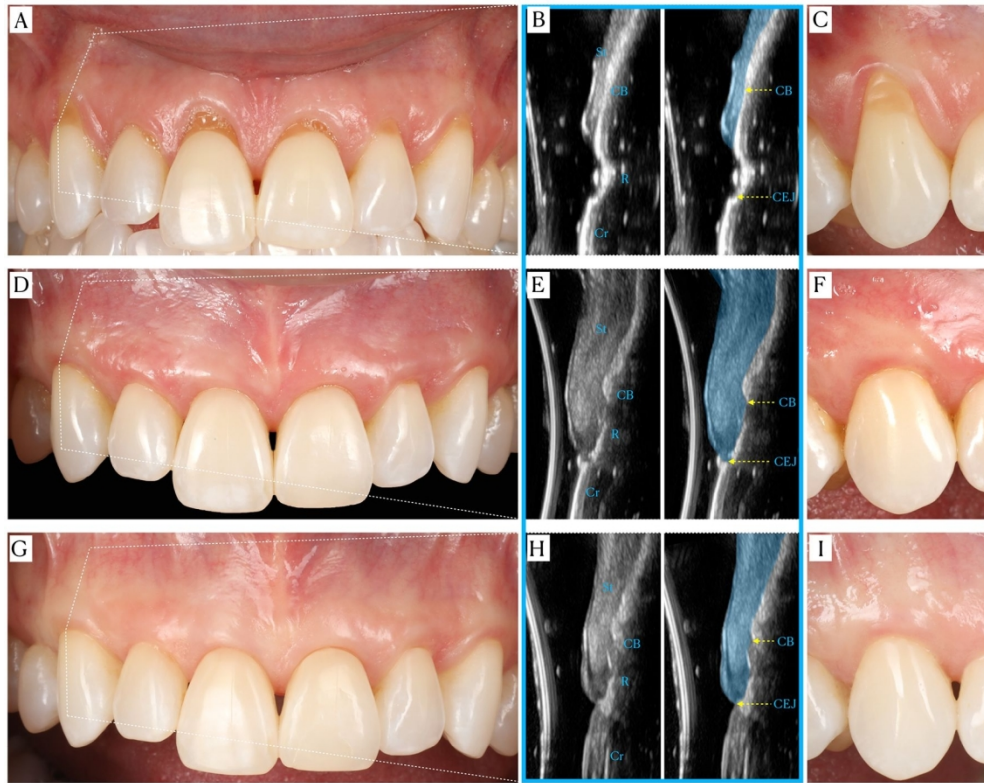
Clinical and ultrasonographic outcomes of the case 1. A) Baseline. B) Ultrasonographic scan of the midfacial aspect of tooth #6, where the clinical crown ("Cr"), the root ("R"), the crestal bone "CB", the cemento-enamel junction ("CEJ") and the soft tissue ("St") are pointed out. Note that the CEJ, CB and the soft tissue are highlighted in the second scan. C) Clinical presentation of the canine at baseline. D) 6-month outcomes. E) Ultrasonographic scan of the midfacial aspect of tooth #6 at 6 months. Note the reduction of buccal bone dehiscence (distance between CEJ and CB) compared to the baseline. F) Clinical presentation of the canine at 6 months. G) 18-month outcomes. H) Ultrasonographic scan of the midfacial aspect of tooth #6 at 18 months. Note the reduction of buccal bone dehiscence (distance between CEJ and CB) compared to the baseline. I) Clinical presentation of the canine at 18 months.
